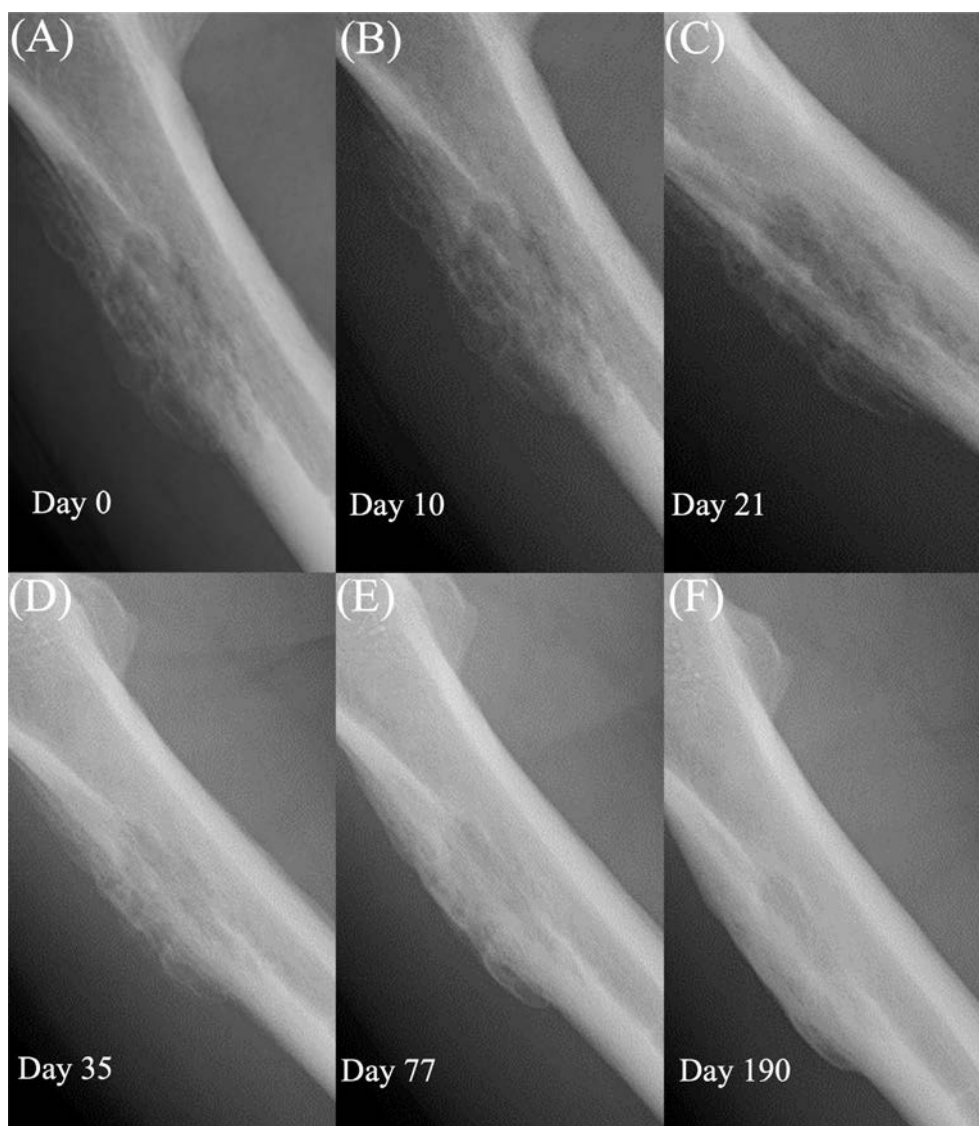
Temporal changes in X-ray images over the course of treatment. (A) Day 0; (B) Day 10; (C) Day 21; (D) Day 35; (E) Day 77; (F) Day 190 of antibiotic treatment.
